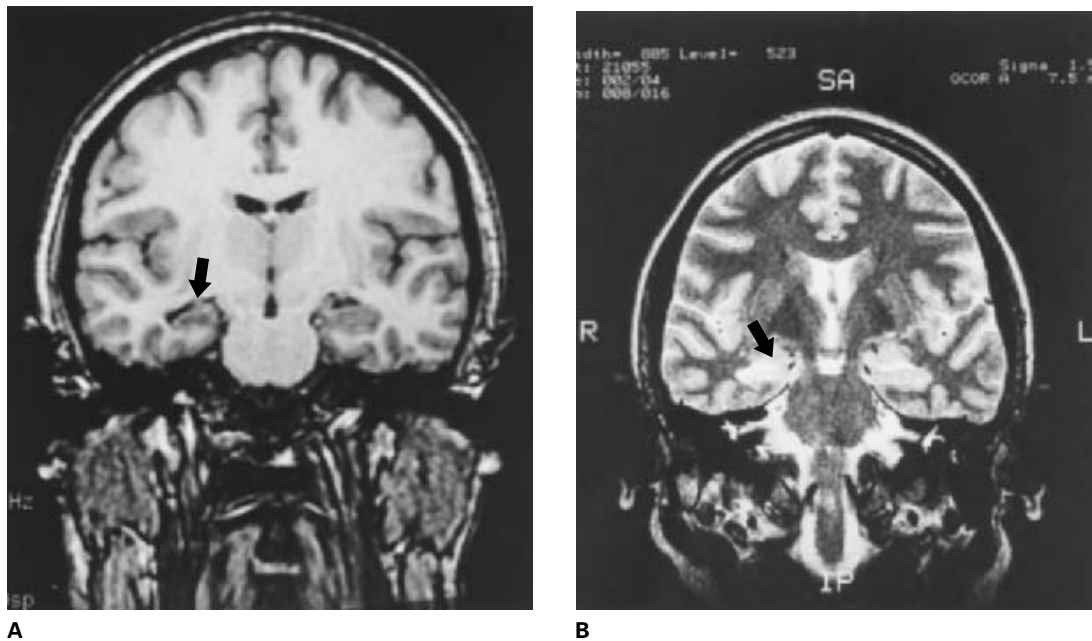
Medial temporal sclerosis. A. Thin-slice volumetric MRI in the coronal plane, showing shrinkage of the right hippocampus (shown by arrow) and secondary enlargement of the temporal horn of the lateral ventricle. B. T2-weighted image showing signal change in the hippocampi (shown by arrow). (Courtesy of Dr. Peter Williamson.)
